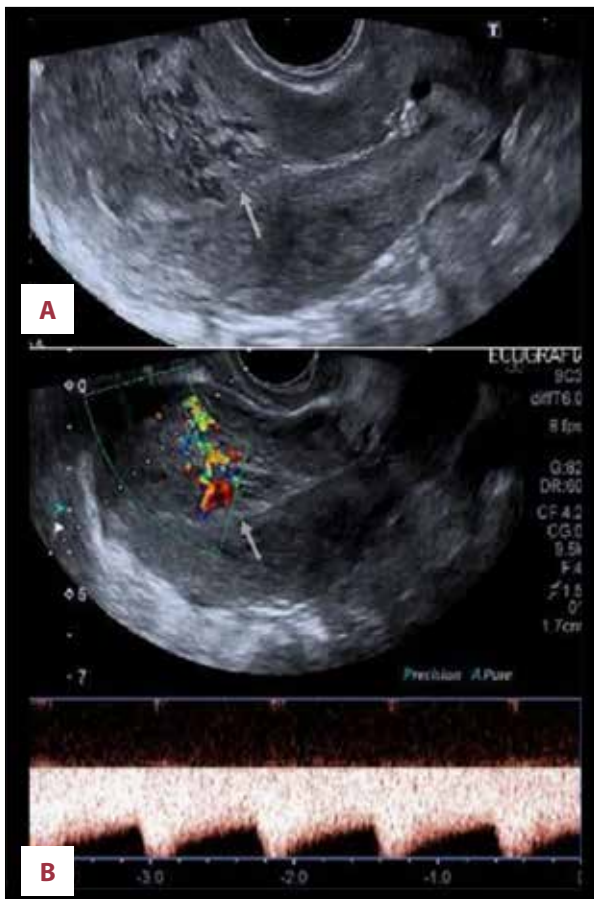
Color and spectral Doppler sonograms. A tangle of vessels (arrow) with multidirectional, turbulent flow with a color mosaic pattern (A) and a high flow, low resistance blood flow pattern (B).
